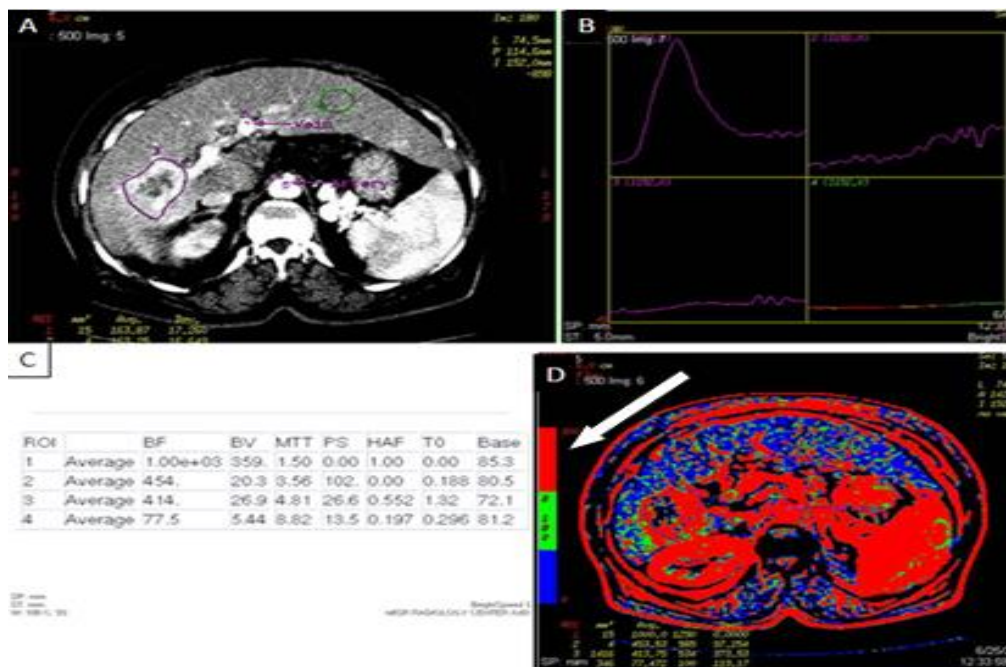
An example of CT perfusion data analysis in a case of HCC:
